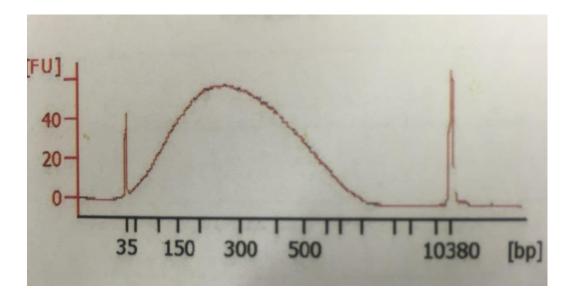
The product of ultrasonification using HL1204 shows a band size of 300bp. This DNA size was used for library preparation of all African isolates.
